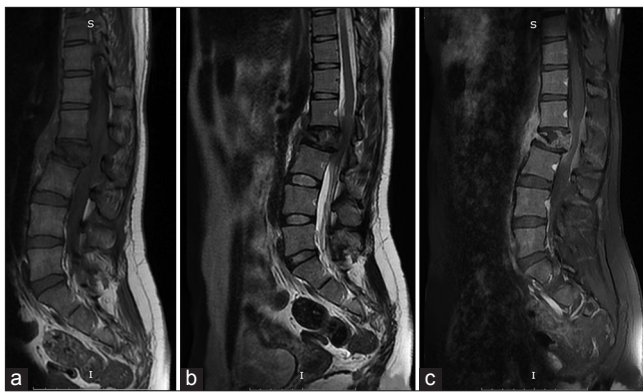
Sagittal T1-weighted (a), T2-weighted (b), and T1-weighted postgadolinium (c) magnetic resonance images showing an hypo intense and enhancing L2 vertebral body tumor extending posteriorly into the spinal canal and causing major thecal sac compression
